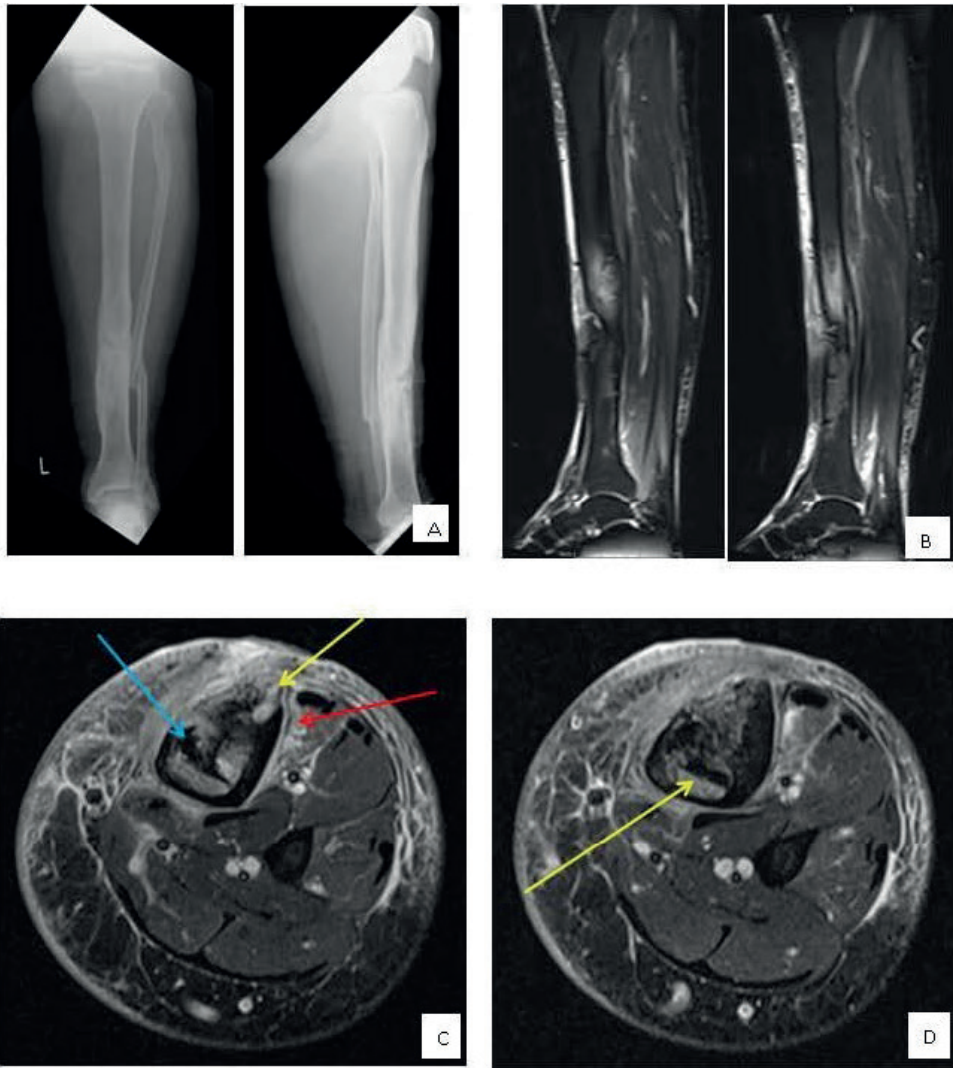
Clinical example MRI. A 54 year old man with a history of an open fracture treated with a plate many years ago. The fracture healed slowly and then the plate was removed because of continued skin breakdown over the front of the tibia. A Frontal and lateral radiograph demonstrating sclerosis and chronic periosteal reaction around the previous fracture site. B Sagittal fat suppressed images of the calf demonstrating bone and soft tissue oedema C & D Axial fat suppressed images demonstrating sequestra (blue arrow), cortical abscesses (yellow arrows) and periostitis and soft tissue oedema (red arrow).
